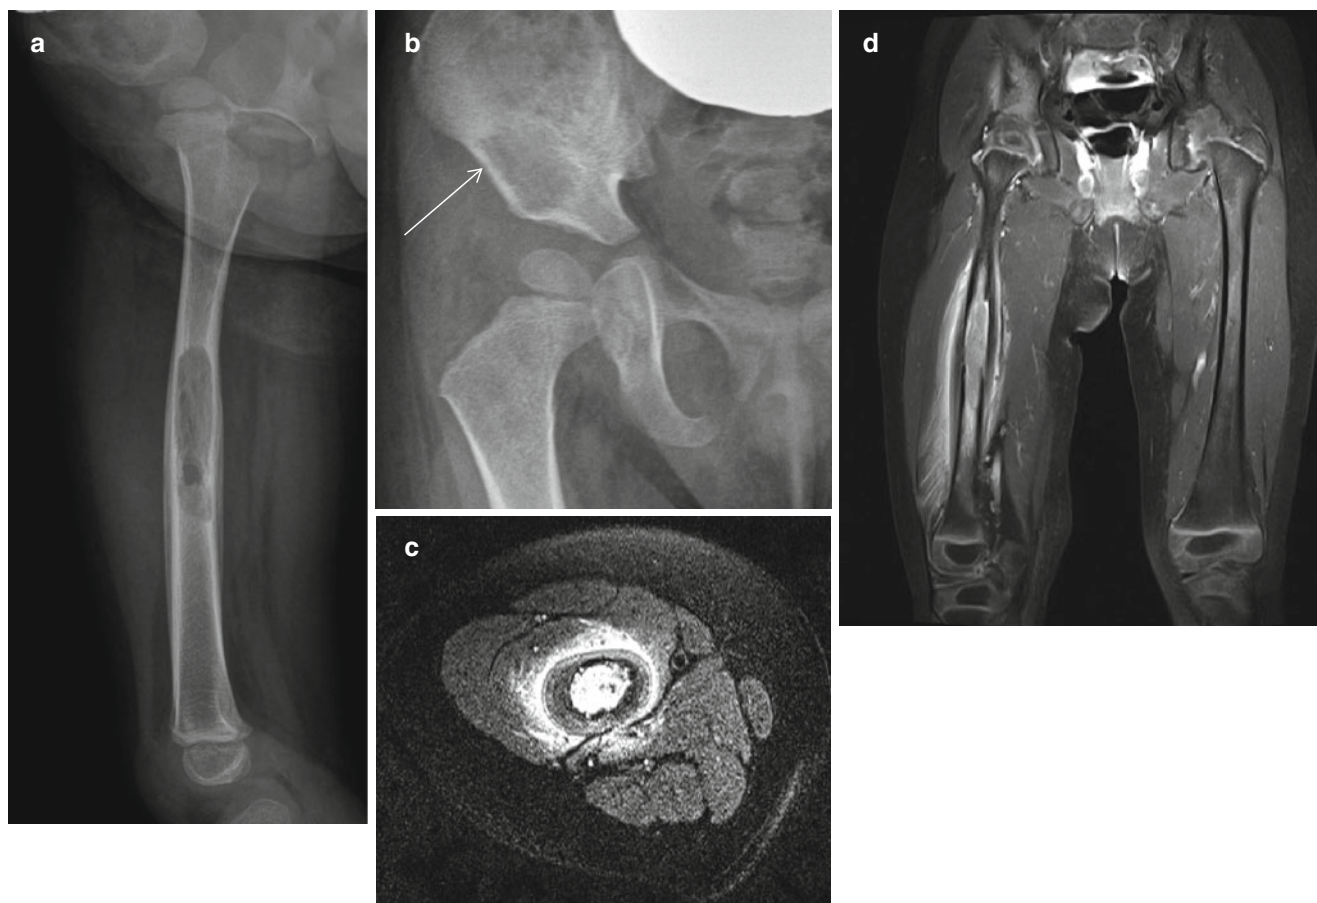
Langerhans cell histiocytosis.* (a, b) Plain radiographs show well-demarcated osteolytic lesions involving the midshaft of the right femur and right acetabulum (arrow). Note the solid-type periosteal new bone formation in the right femur. (c, d) Axial T2 SPAIR
